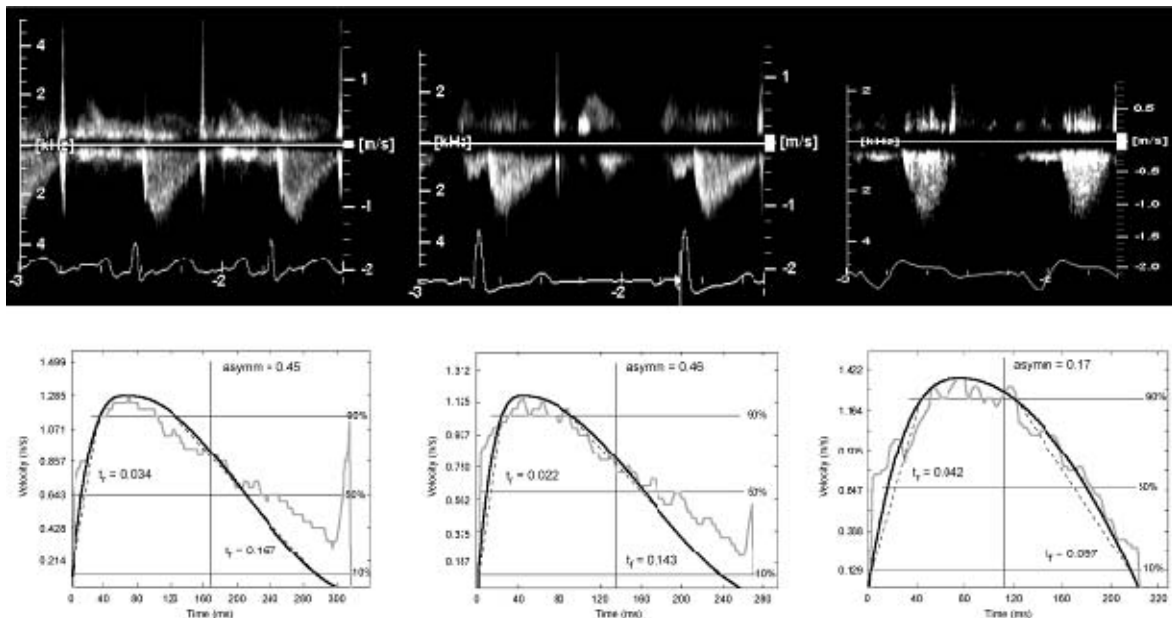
Raw CW Doppler trace and extracted profile from the control group (left), DSE negative group (middle) and DSE positive group (right).
